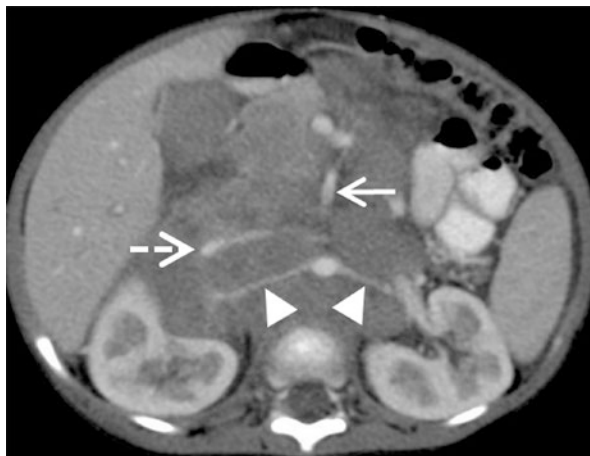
A 2-year-old boy with metastatic abdominal neuroblastoma (MYCN amplified, INSS stage 4, INRGSS M). Contrast-enhanced transverse CT scan view. The tumour demonstrates moderate and homogeneous enhancement. It arises from the periaortic sympathetic fibres and encases both renal pedicles (arrowhead), the superior mesenteric artery (arrow) and the inferior vena cava (dotted arrow)
